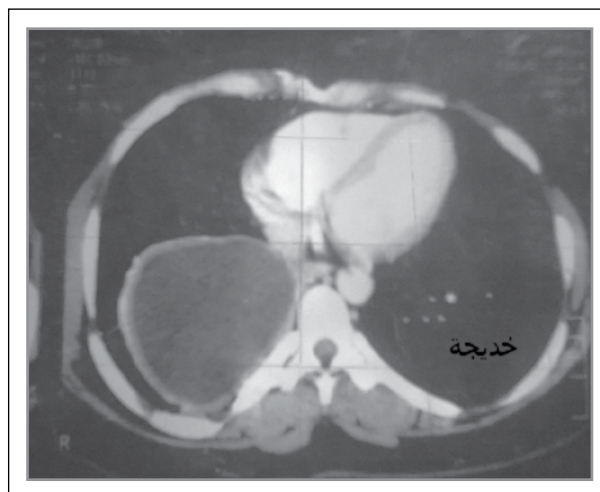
CT chest scan (mediastinal window) showed large hydatid cyst in right lower lobe.
